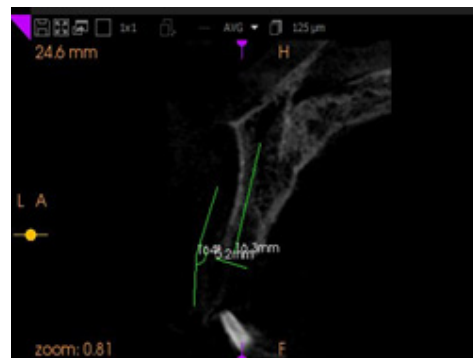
Sagittal view of CBCT X-ray before implant placement
